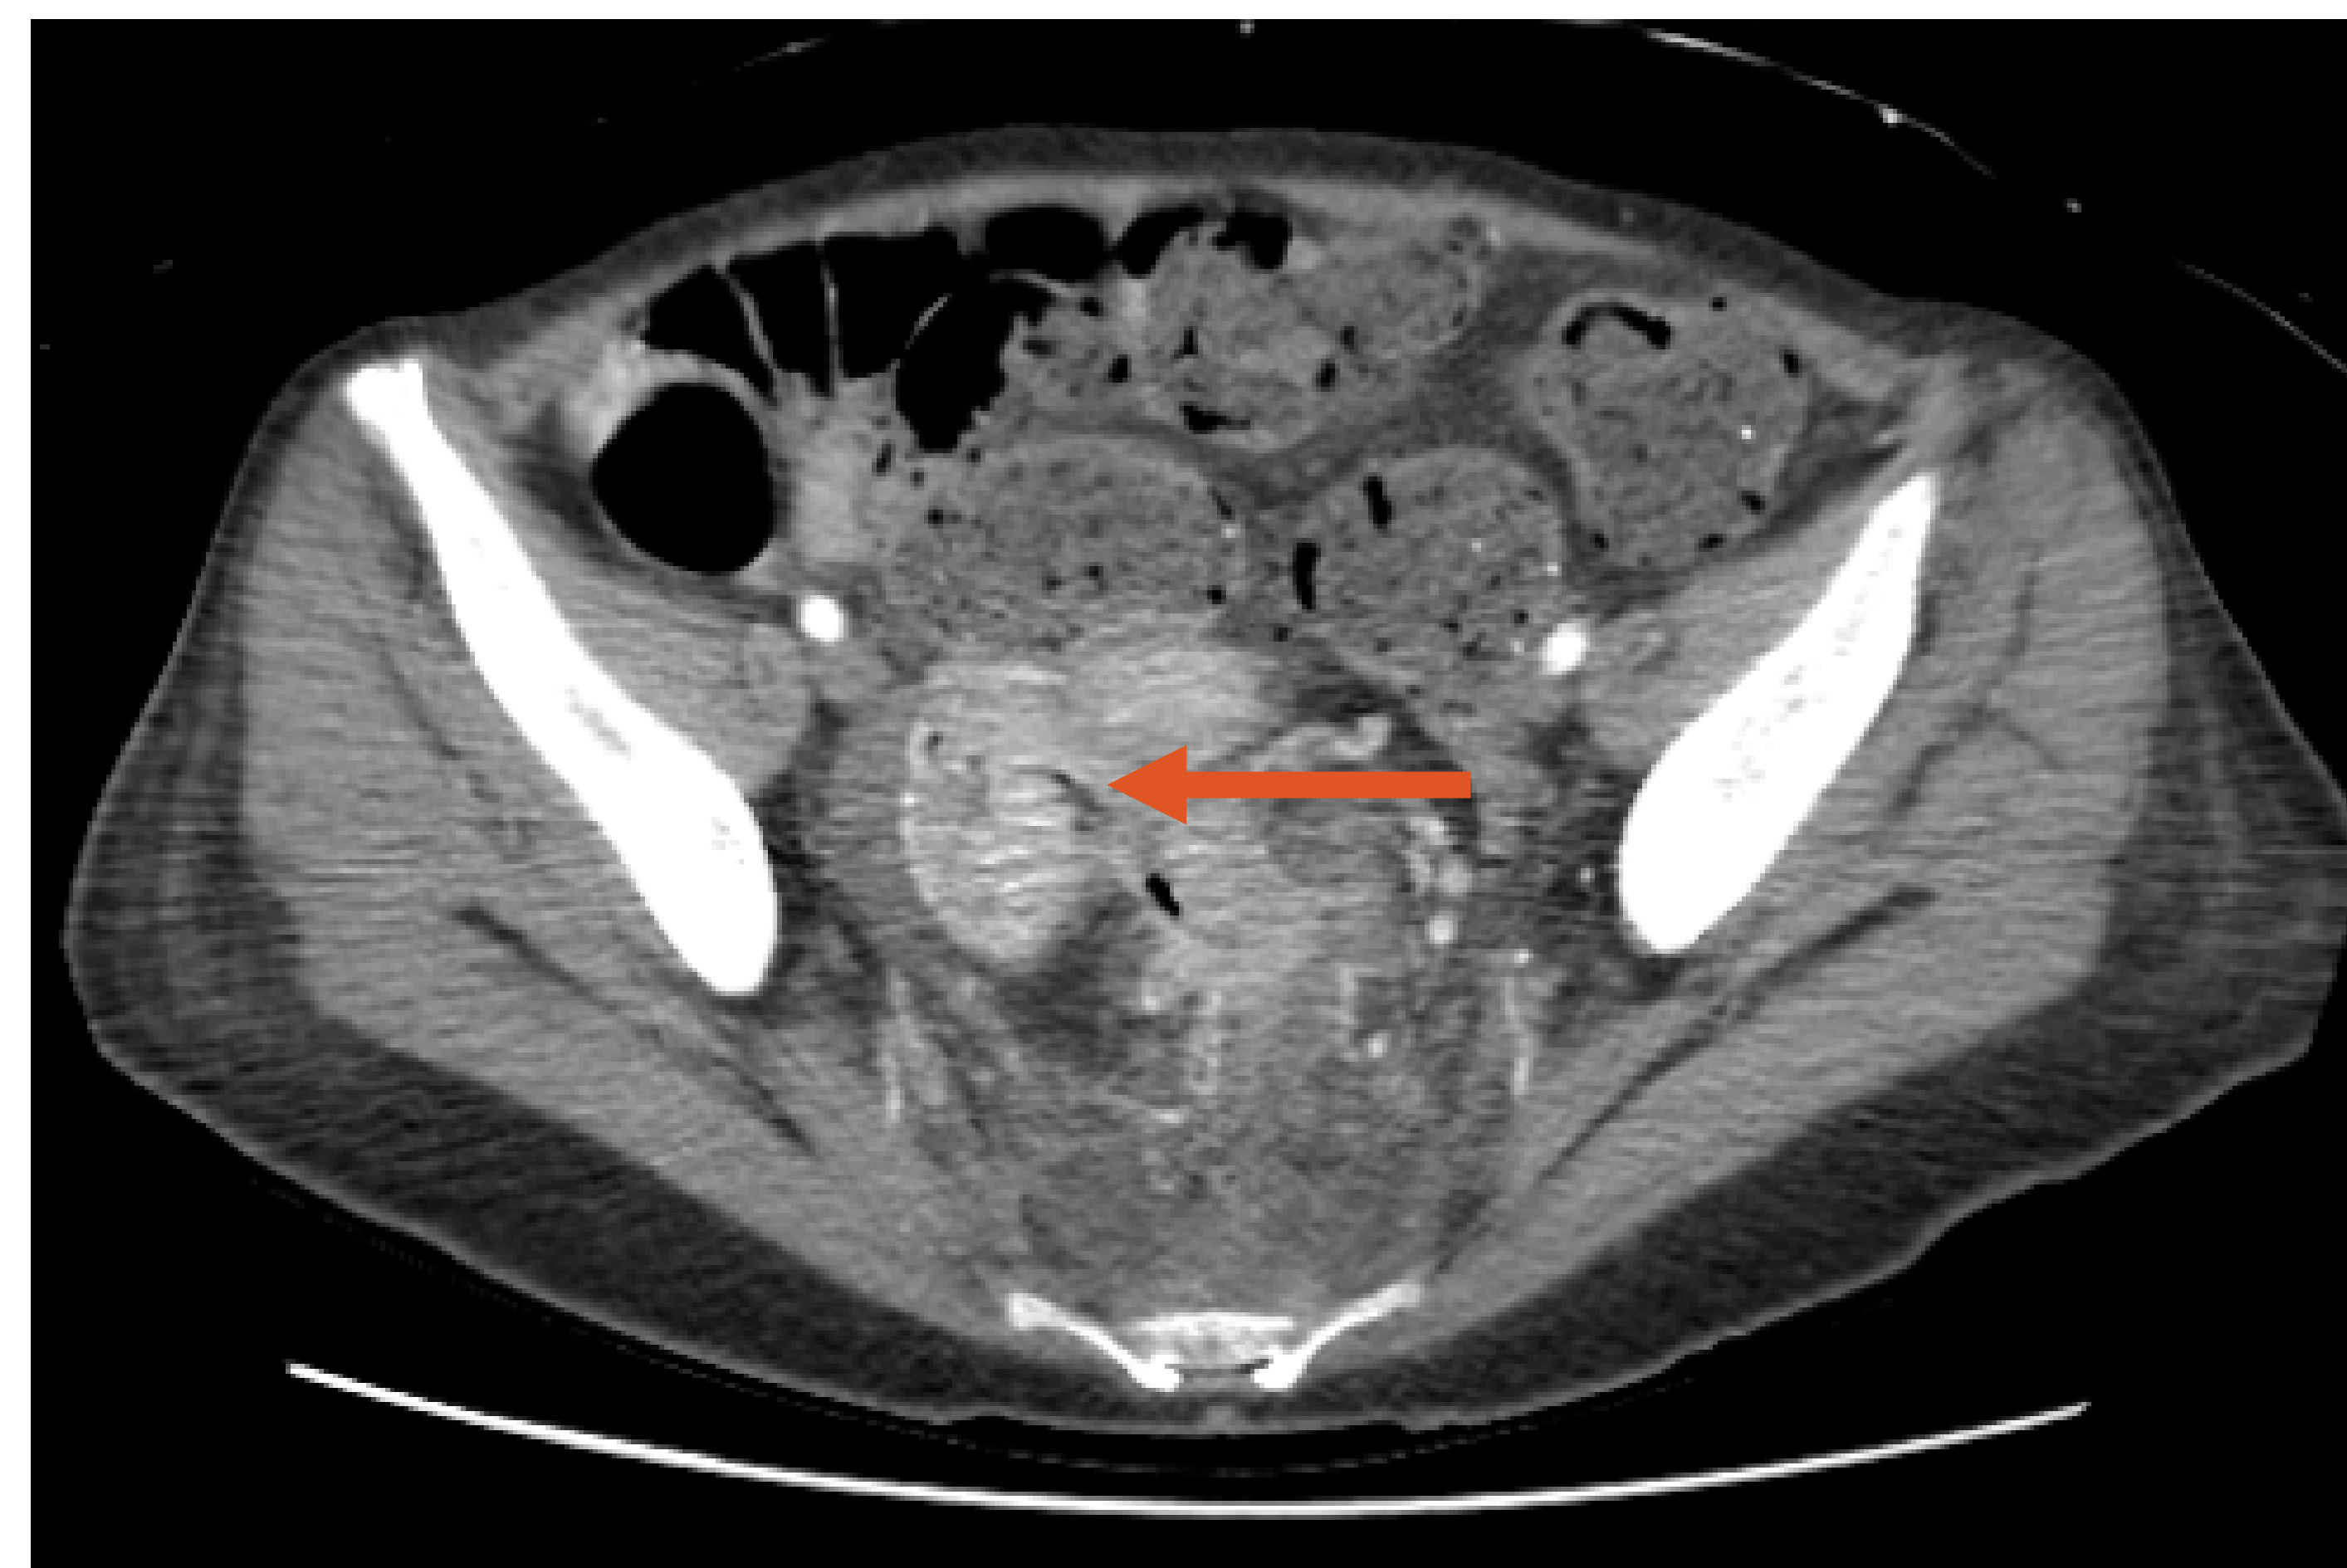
Axial View CT Abdomen/Pelvis Without Contrast showing Inflammation and Contiguous Spread of Colonic Adenocarcinoma to the Adjacent Small Bowel (Orange Arrow).
